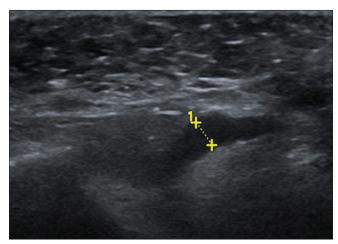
Ultrasound scan: Parotid duct dilatation
